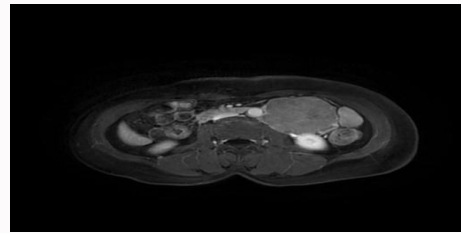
Axial T1 weighted MRI showing a large hypo intense mass in the posterior abdominal wall.
